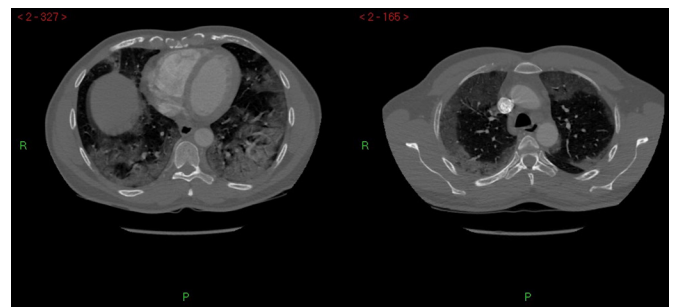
CT chest demonstrating bibasal and peripheral ground glass opacification and patchy more confluent consolidation in keeping with COVID-19 pneumonia.
